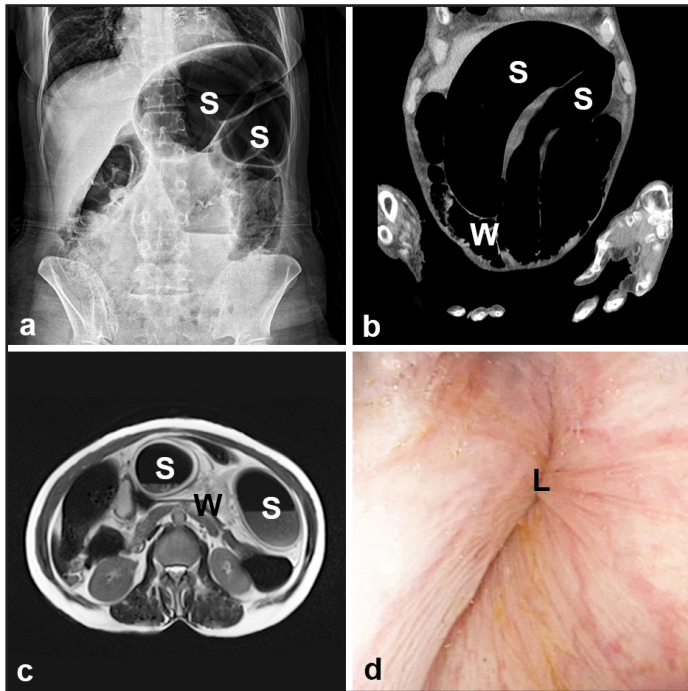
a. Abdominal X-ray radiograph of sigmoid volvulus b. Abdominal coronal computerized tomography image of sigmoid volvulus. c. Abdominal axial magnetic resonance image of sigmoid volvulus. d. Endoscopic appearance of sigmoid volvulus (S: dilated sigmoid colon segments, W: mesenteric whirl sign, L: Spiral-like obstructive sigmoid lumen).
